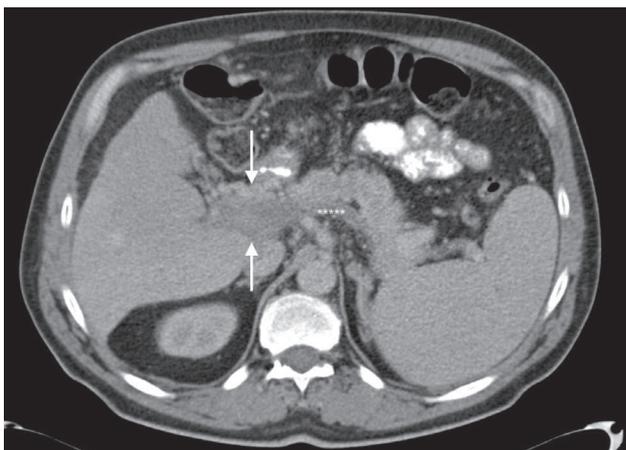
Abdomen/pelvis computed tomography (CT) scan. Between white arrows a dilated, thrombosed portal vein is shown with multiple vascular collaterals in keeping with portal vein cavernous transformation. The white asterisks indicate the splenic vein which is also thrombosed. The superior mesenteric vein thrombosis is not shown in this figure.
